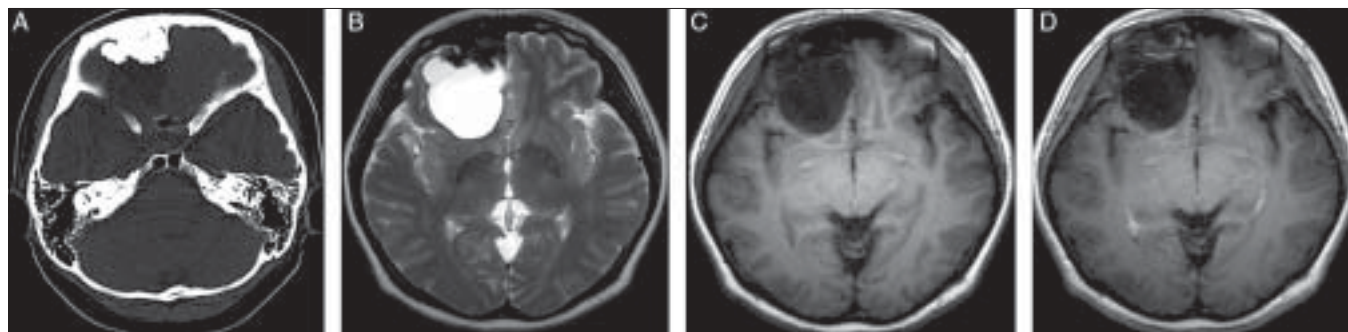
(A) Axial CT scan demonstrating a calcified mass localized in the right anterior cranial fossa with intracranial and frontal sinus extension. (B, C, D) MRI showing the cystic lesion is hypo-intense on T1-weighted images and hyper-intense on T2-weighted images. After contrast linear enhancement can be found along the cystic wall
